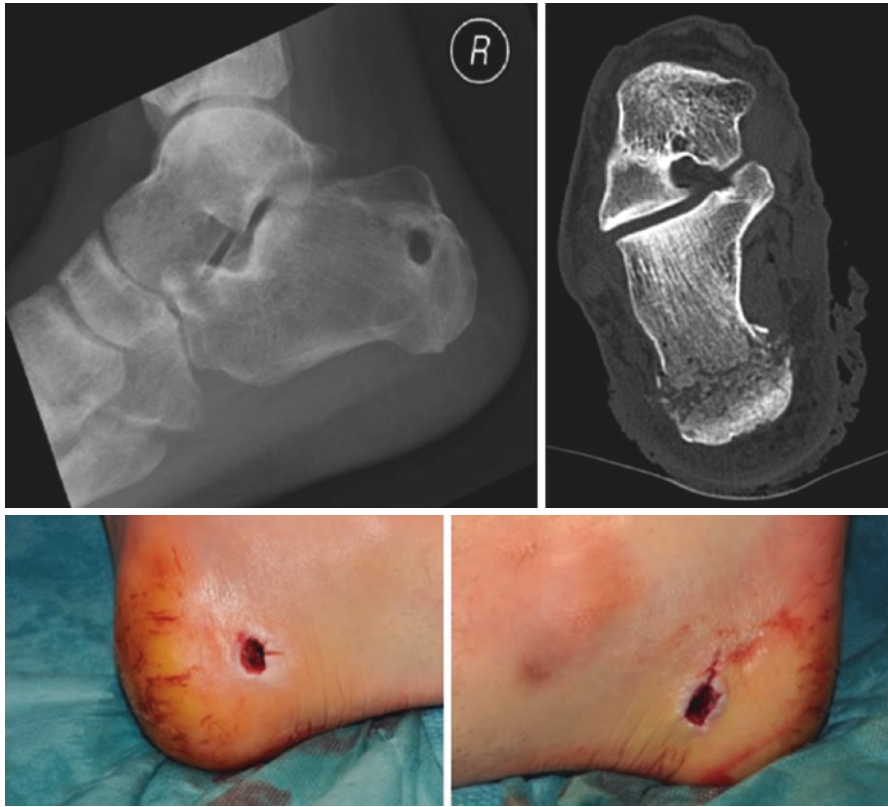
Radiograph, CT image and clinical photographs showing a gun-shot wound to the heel with a low-energy open fracture of the calcaneum. There has been little energy transferred and the wound healed without complication only requiring superficial scrubbing of the entry and exit wounds and irrigation with saline. © 2017 Crown Copyright
